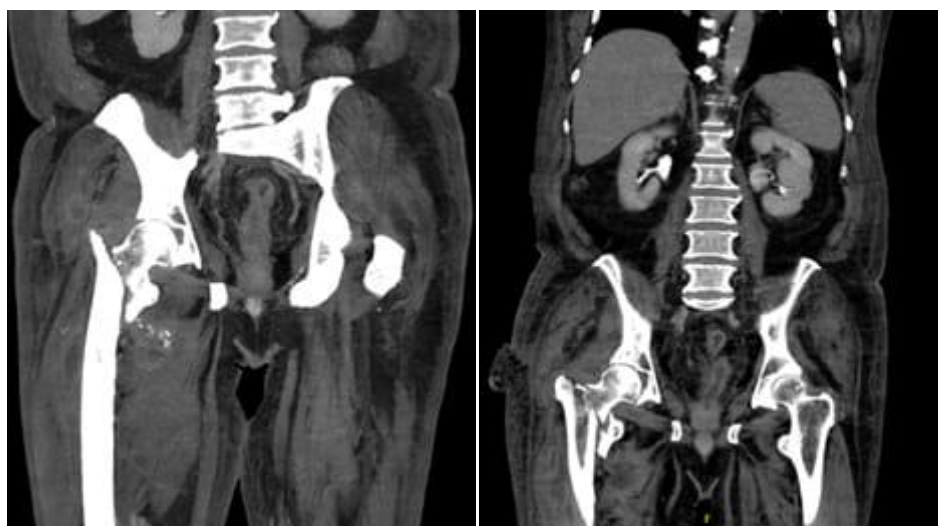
Preoperative computed tomography (coronal plane).
